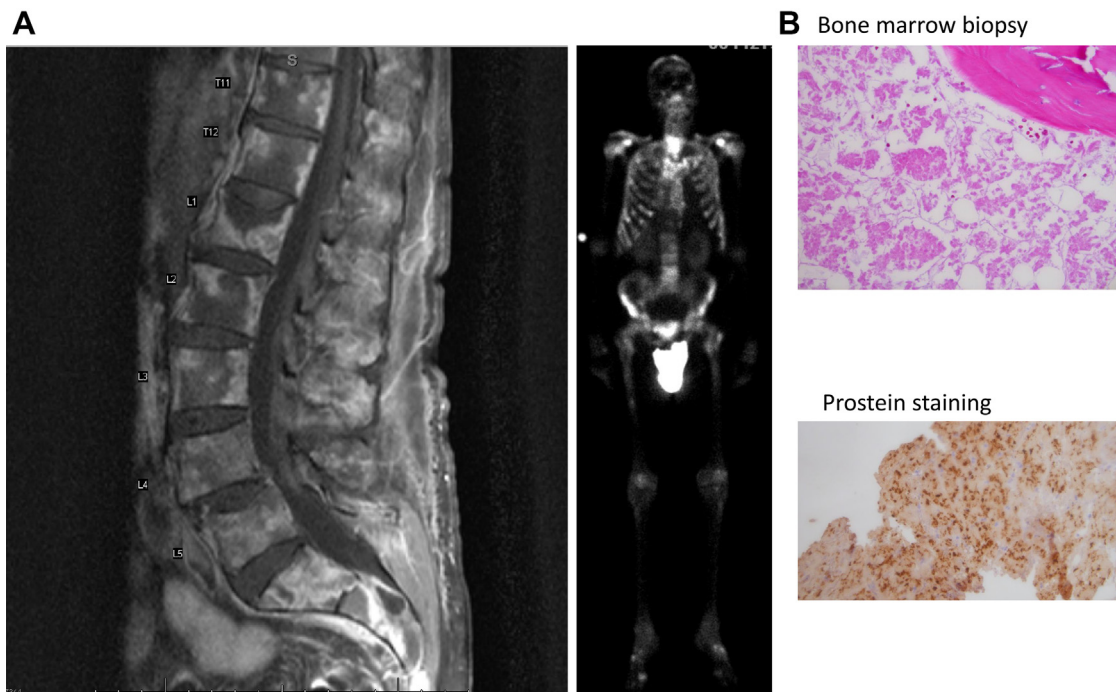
A) MRI and nuclear medicine bone scan demonstrating diffuse widespread osseous metastases. B) Bone marrow with extensive necrosis, consistent with infiltrating tumor.
